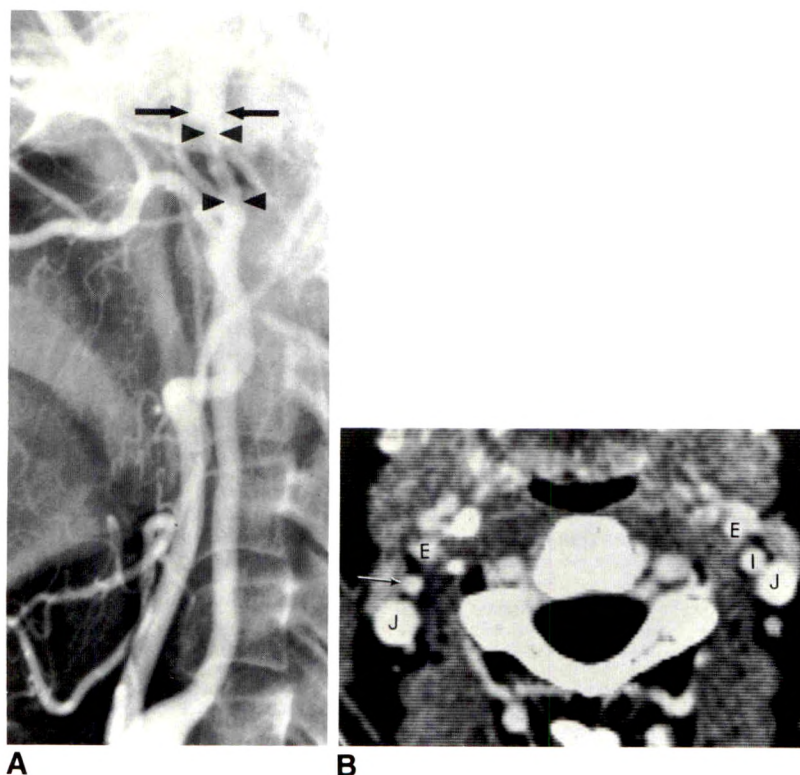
Overestimation of longitudinal extent of internal carotid artery dissection by angiography in a 39-year-old woman with right-sided headache, neck soreness, and intermittent transient ischemic attacks. A, Three days after initial symptoms, right common carotid arteriogram (lateral projection) shows diffusely narrowed cervical internal carotid artery with irregular, more severe narrowing distally (arrowheads) and abrupt reconstitution of lumen at its entrance into carotid canal (arrows). B, Proximally, axial CT image reveals relatively small lumen of right internal carotid artery (arrow) but without mural thickening to indicate dissection at this level (I = internal carotid artery, E = external carotid artery, J = internal jugular vein).
